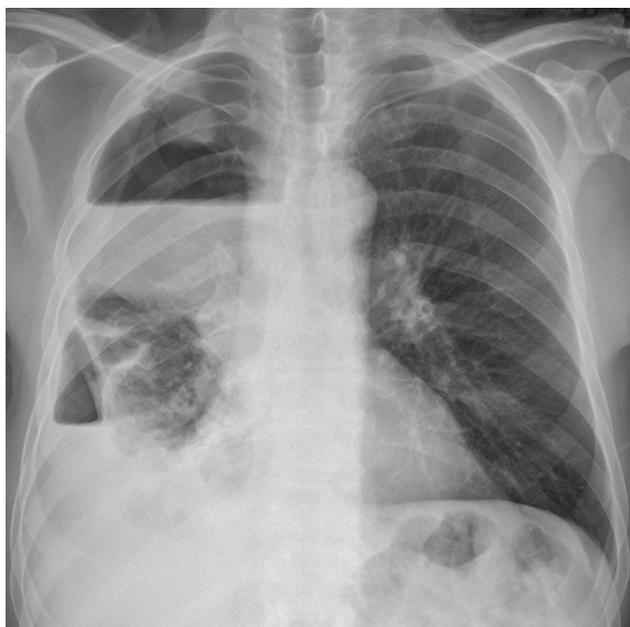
Chest X-ray before the VATS.
